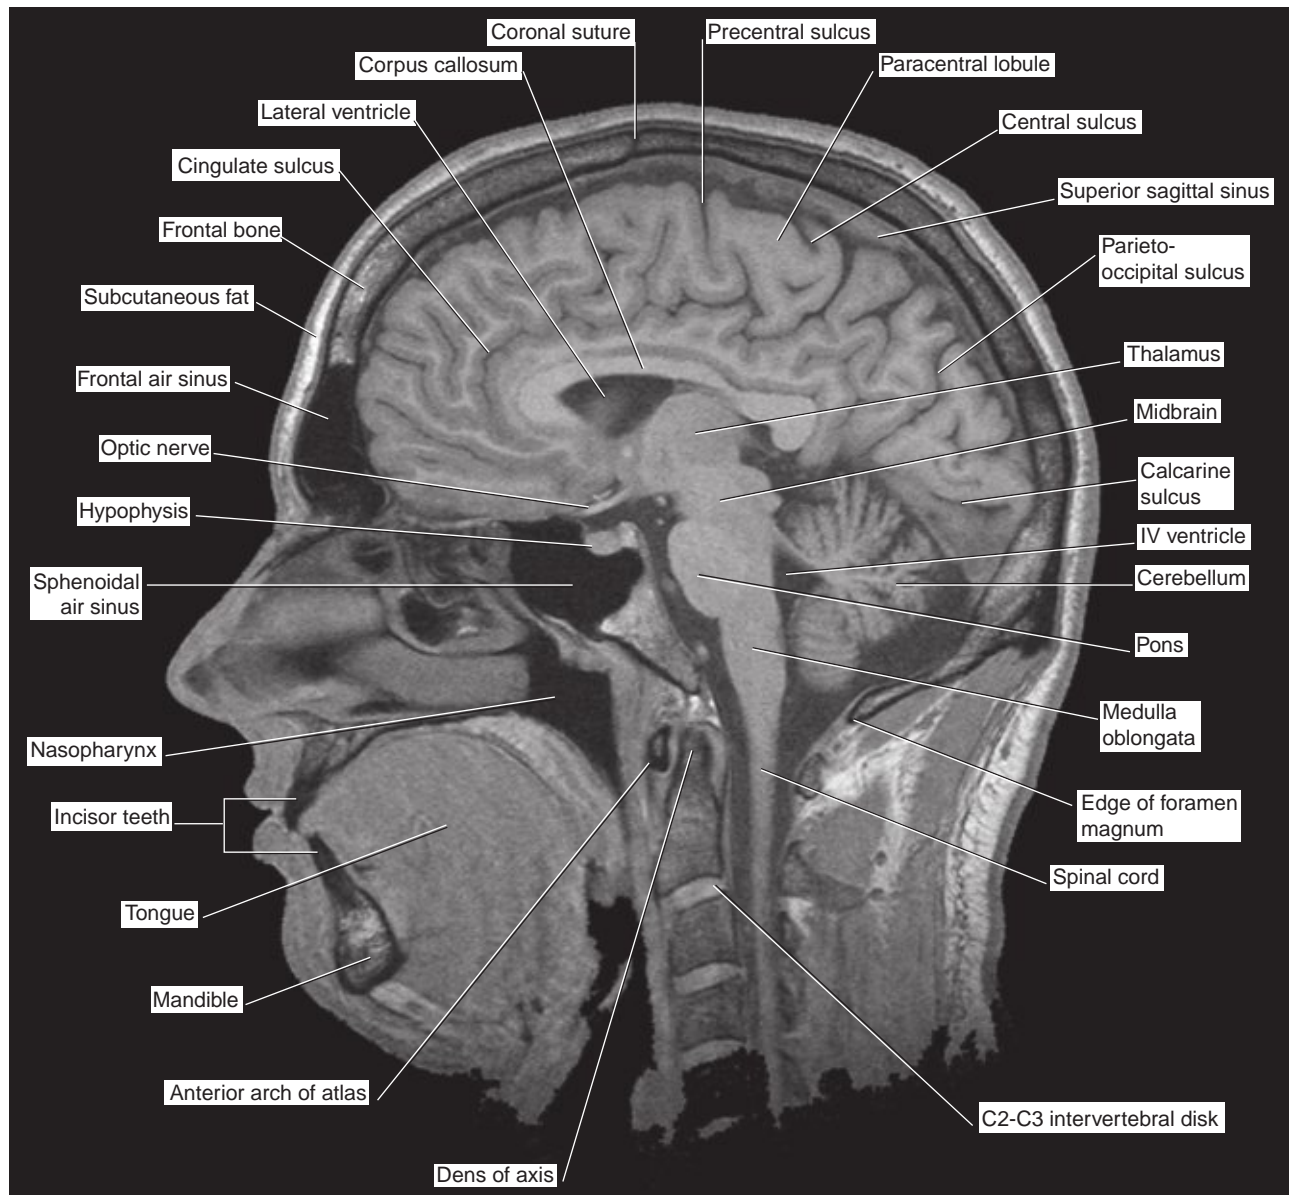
Sagittal MRI 'slice' of the living brain. (From a series kindly provided by Professor J. Paul Finn, Director, Magnetic Resonance Research, Department of Radiology, David Geffen School of Medicine at UCLA, California, USA.)
